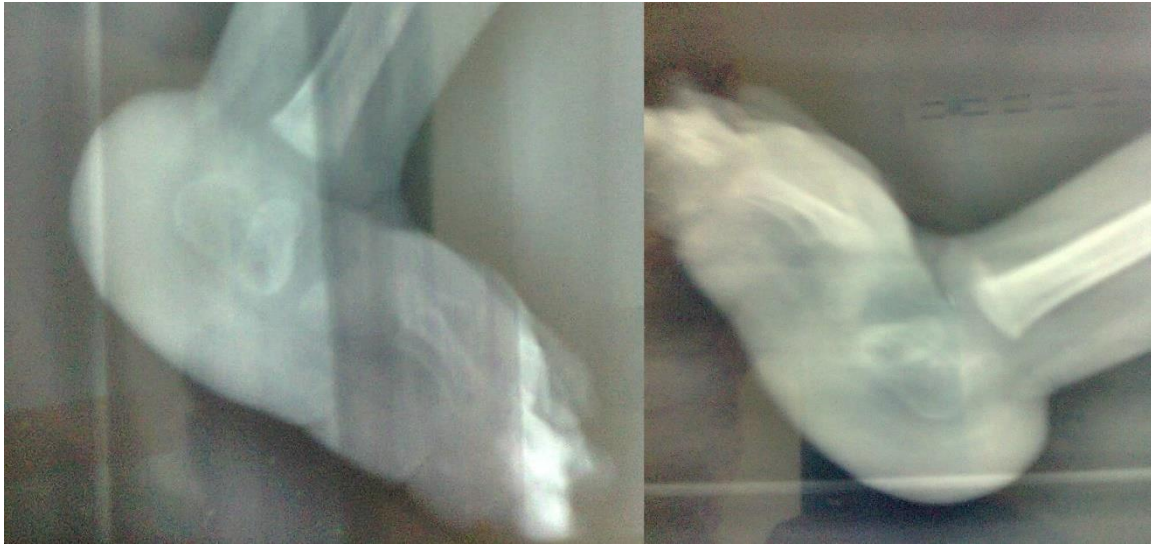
Radiographs showing normal positioning of talus, and thus the deformity represents a pseudo rocker bottom feet
